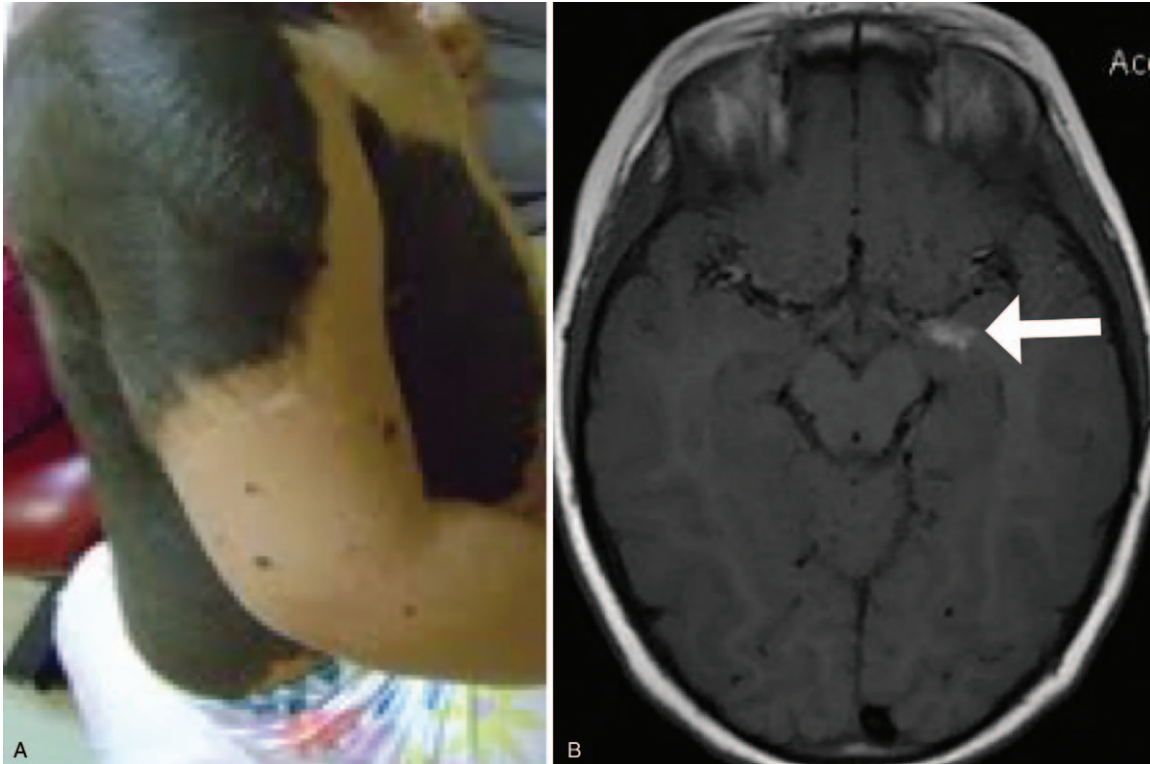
Male child with neurocutaneous melanosis presenting with a giant melanocytic nevus involving the dorsal region, posterior cervical region, right arm, and anterior abdominal wall (A). Axial unenhanced T1-weighted image (B) shows a hyperintense nodular/linear lesion in the left amygdala, consistent with melanin deposition (white arrow).
